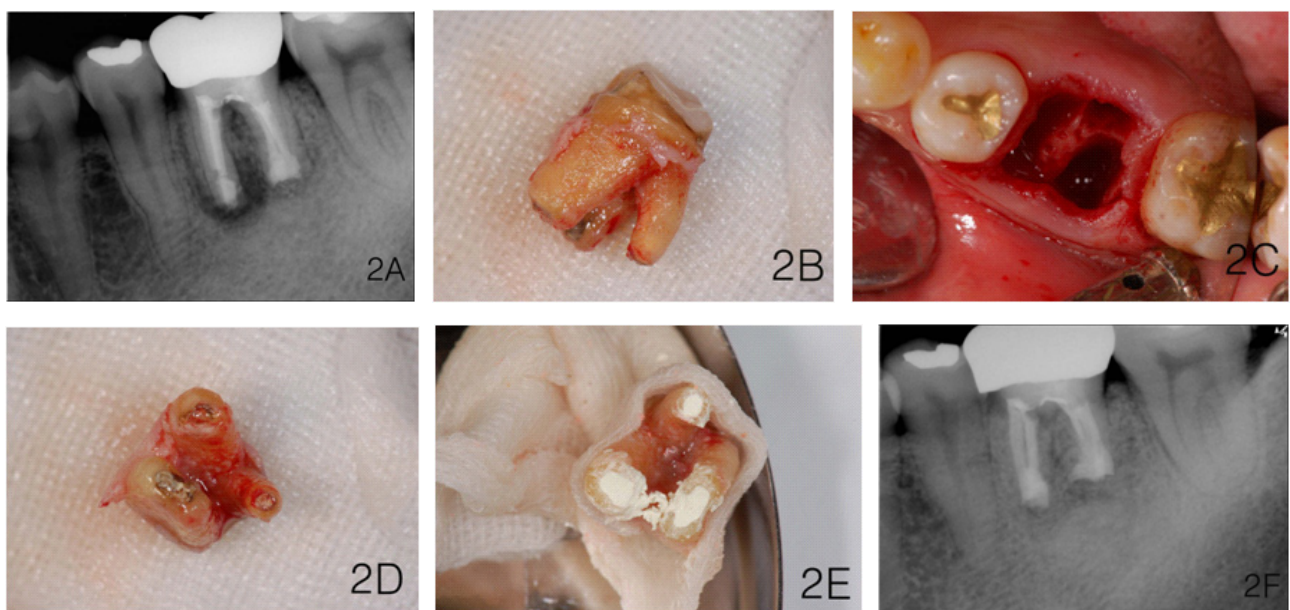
(A) A periapical radiograph shows recurrent apical radiolucency on the mesial root of the first molar. (B) Through the extracted teeth, it could be verified that there was no external root resorption or ankylosis (C) The extraction socket and soft tissue were clean, and no alveolar bone fracture was observed. (D) Contamination of the retrograde filling material, MTA, had been caused by a microleakage, which was the main cause of the failed first IR. (E) The retrograde preparation and filling with MTA. (F) About 2 years after the second IR, the tooth was still asymptomatic and showed normal pocket depth and periodontal ligament space.
